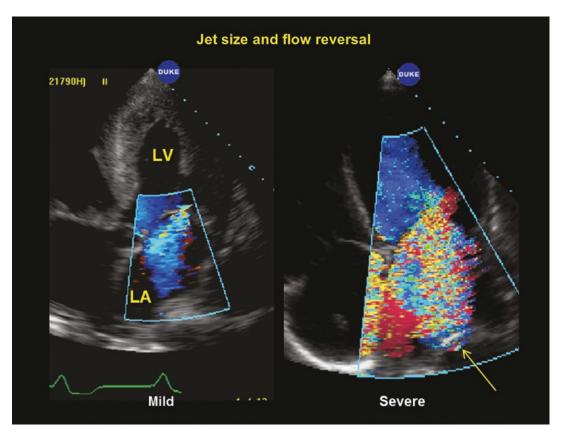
Apical four chamber views from two different patients, one with mild and the other severe mitral regurgitation
